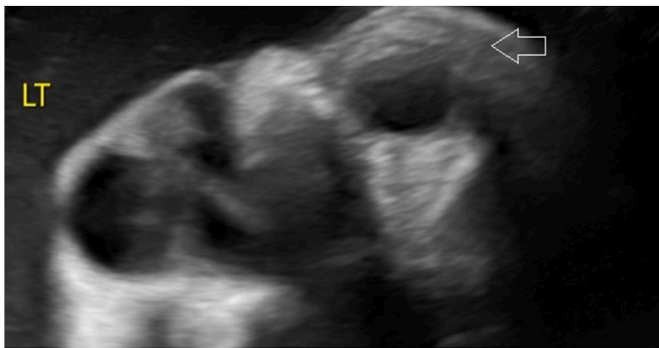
Intrauterine ultrasound at the 34th week of gestation demonstrating a left orbital cystic lesion (arrow).
